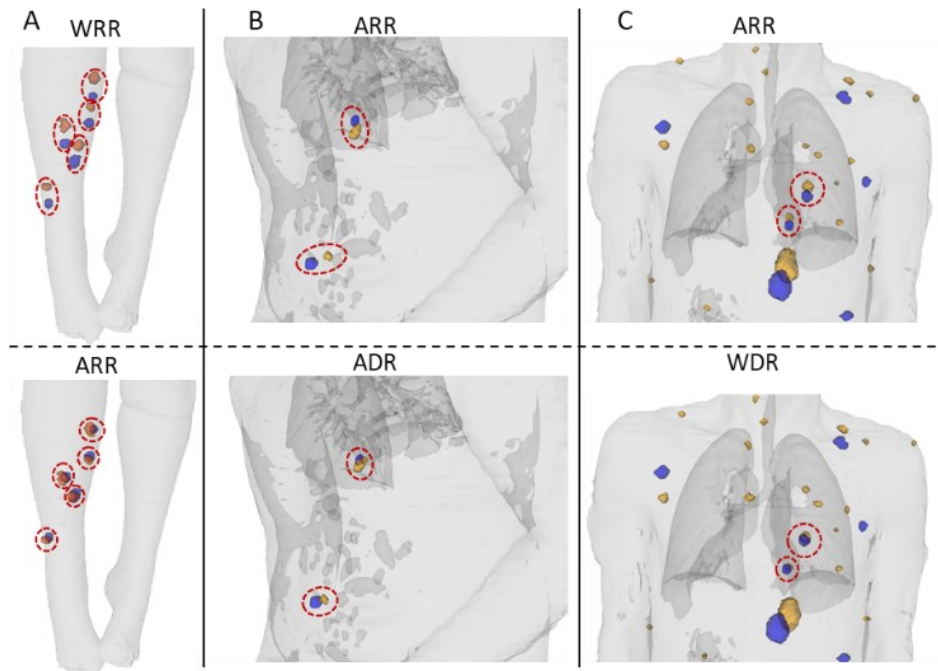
Visualization of the impact of different registrations on proximity of corresponding lesions. The CT contour is shown in light gray. Earlier scan lesions are shown in blue and later scan lesions in orange. Red ellipses highlight the corresponding lesions that had visible proximity. Images are shown for whole-body rigid (WRR), articulated rigid (ARR), articulated deformable (ADR), and whole-body deformable (WDR) registrations. Column (A) compares WRR to ARR. Column (B) compares ARR to ADR. And column (C) compares ARR to WDR.
